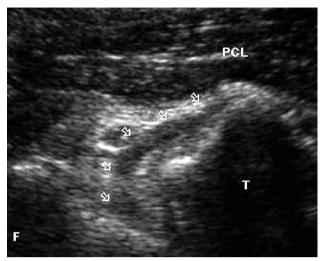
Ultrasound image of normal hypoechoic PCL (arrows) with the probe placed longitudinally in the popliteal fossa. F-Femoral condyle, T-Tibial plateau.
